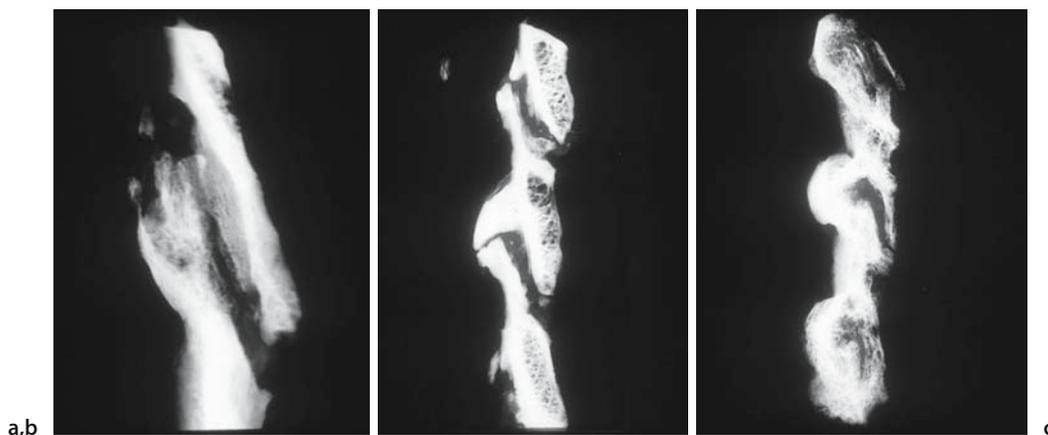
Softex radiographs show the development of ossification of the ligamentum flavum (OLF). a Initial ossification at the attachment of the caudal portion. b Nodular-type OLF.
